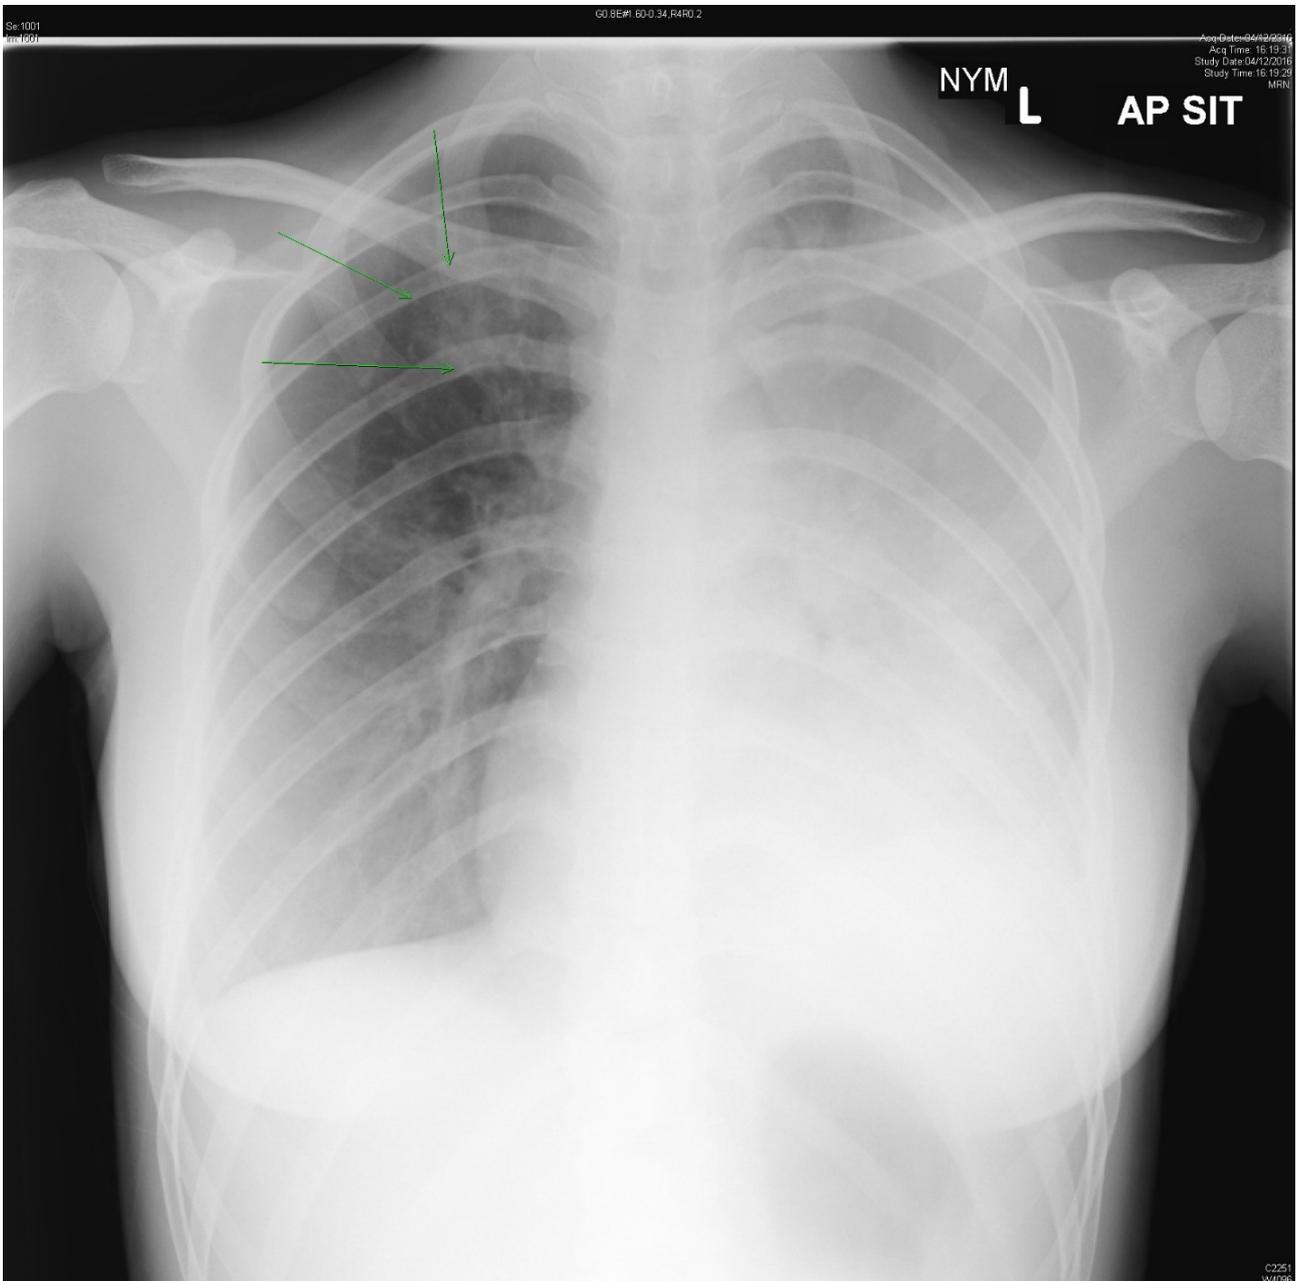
Patient's chest X-ray on admission
